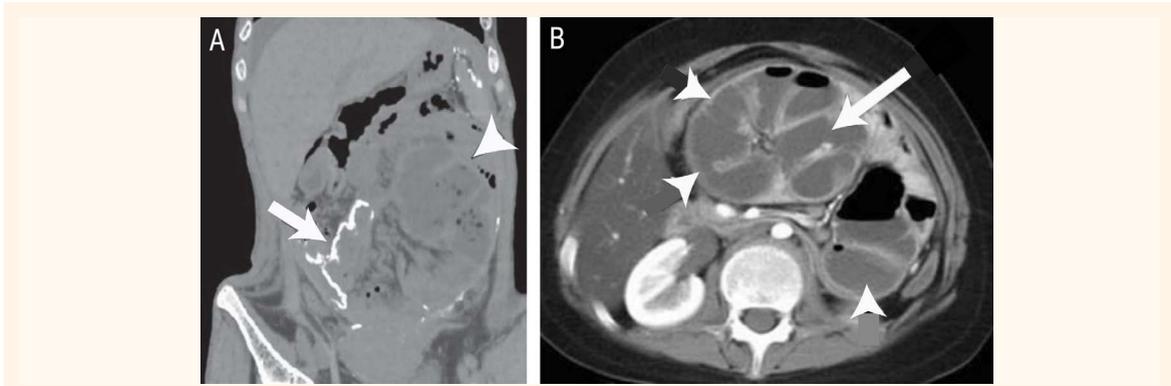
A: Plain abdominal X-ray showing bowel wall calcification (arrow) and peritoneal calcification with centrally clumped dilated small bowel loops (arrowhead) in a patient with sclerosing encapsulating peritonitis. B: Abdominal computed tomography revealing encased loops of bowel (arrow) by a distinct membrane (arrowheads) in a patient with sclerosing encapsulating peritonitis.
